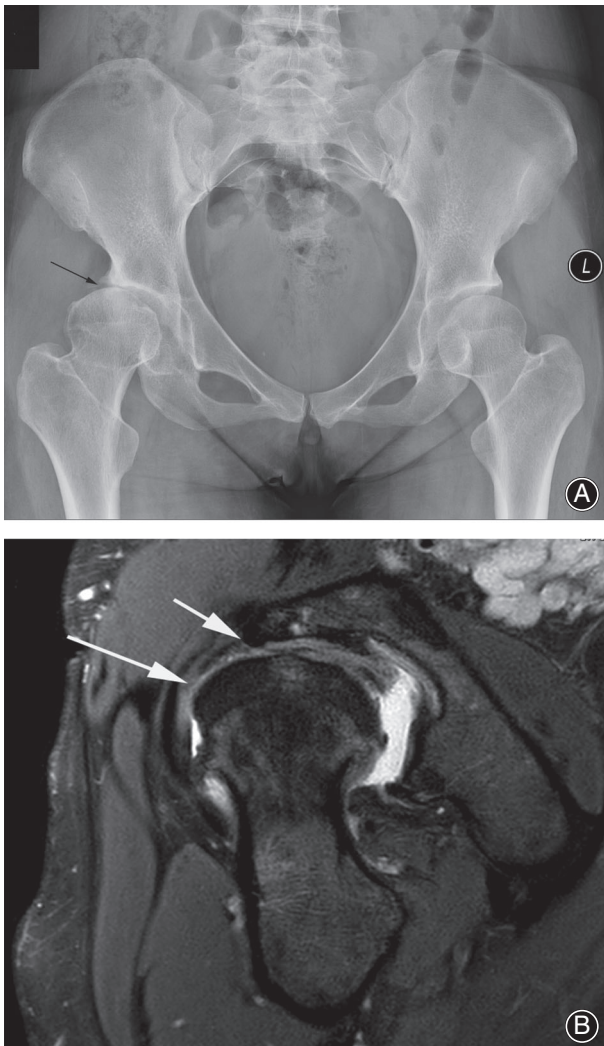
Thirty-nine-year-old woman who was treated with labral debridement, femoroplasty and capsular closure during the arthroscopic surgery for the right hip. The patient complained of severe pain and limitation of the range of motion of right hip 2 years after operation. (A) The final follow-up radiographs showed subluxation of the hip and joint space narrowing (arrow). (B) The MRI showed labral deficient (short arrow) and non-union of the anterior capsule (long arrow).
